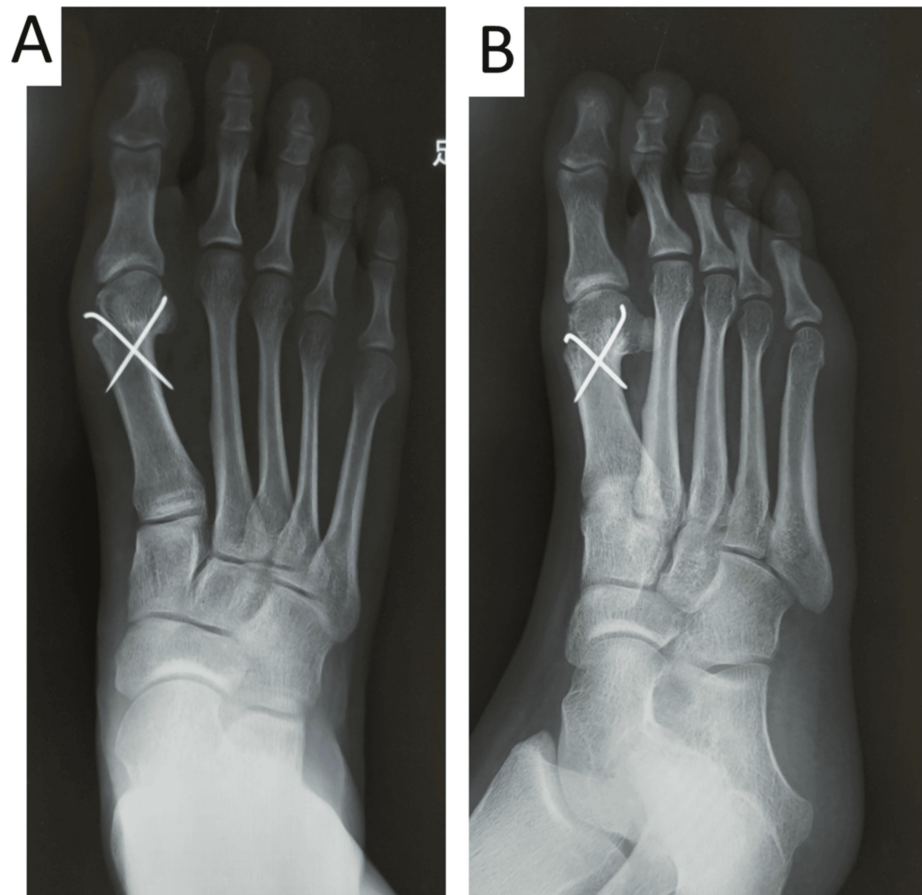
X-ray findings of the right foot (standing) at 12 months postoperatively
